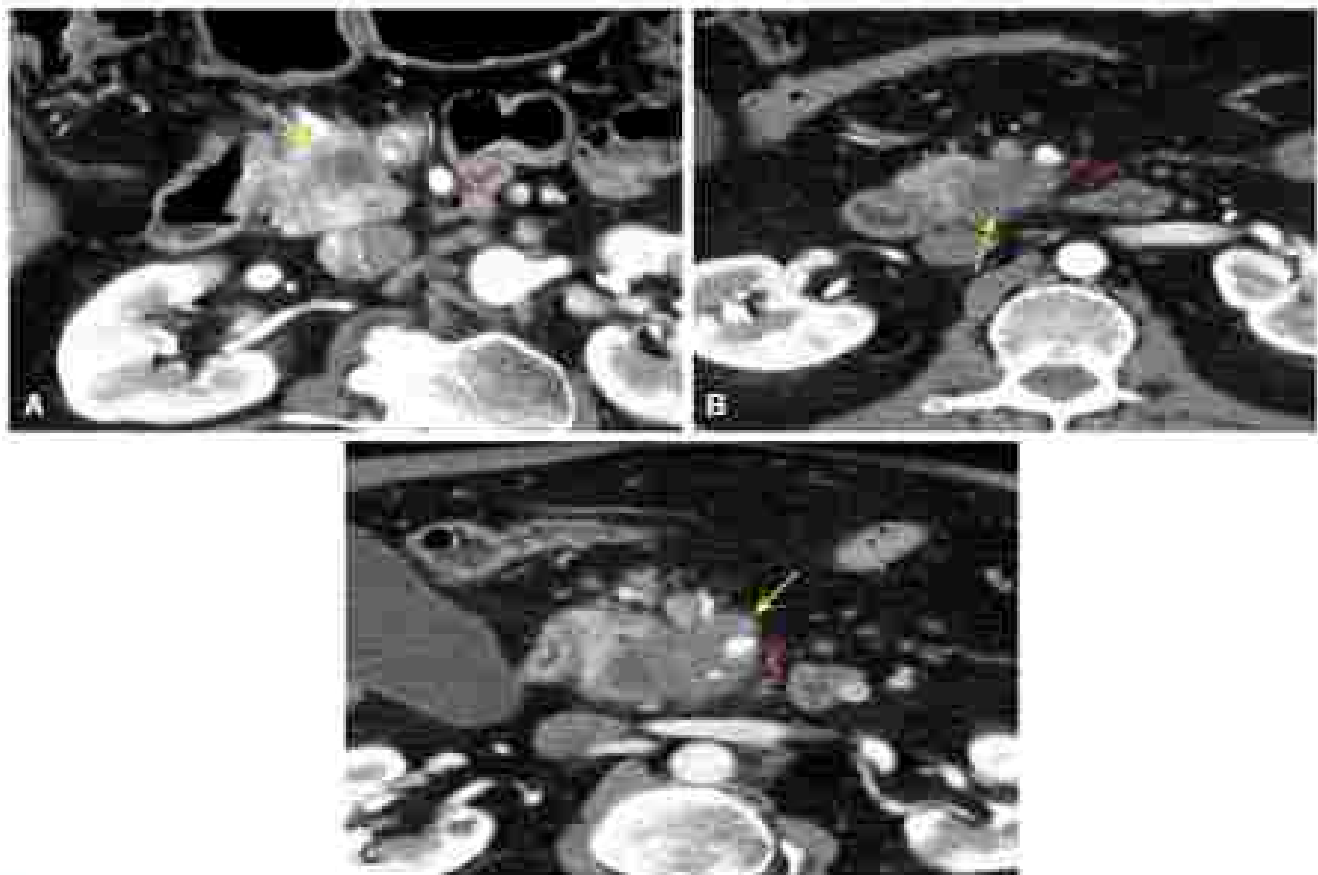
Clinical staging is based on tumor-vein contact. Contrast-enhanced axial computed tomographic images show the tumor (pink arrow), superior mesenteric vein (SMV, blue arrowhead), and superior mesenteric artery (SMA, red arrow). (A) Resectable pancreatic cancer. Hypodense tumor is present in the pancreatic head with preservation of the fat plane between the pancreas and the SMV and without tumor abutment of the SMA. (B) Borderline resectable pancreatic cancer. Note the hypodense tumor that abuts both the SMV and the SMA. (C) Locally advanced pancreatic cancer. The hypodense tumor encases (>180 degrees) the SMA.
